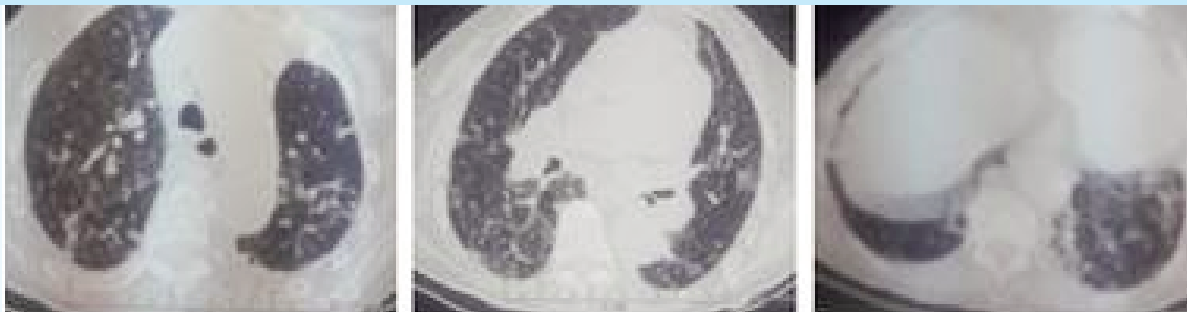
Pulmonary computed tomography after one month of corticosteroids with significant improvement of images: disappearance of pleural effusion and very important reduction of alveolo-interstitial opacities
